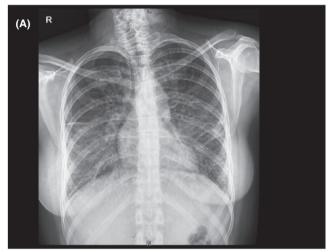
(A) Chest X-ray PA view shows reticular opacities with subtle ground-glass opacities. (B)-Axial CT scan lung window in upper and middle zones of lung shows: Multifocal ground-glass opacities and reticulation
